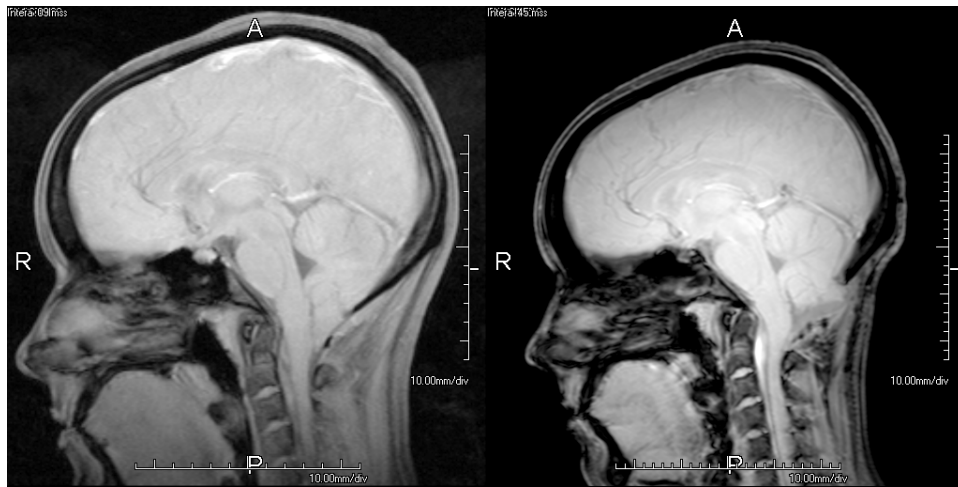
First images of two sets of cine MRI of a patient with CM1 before (left) and after (right) surgery.
